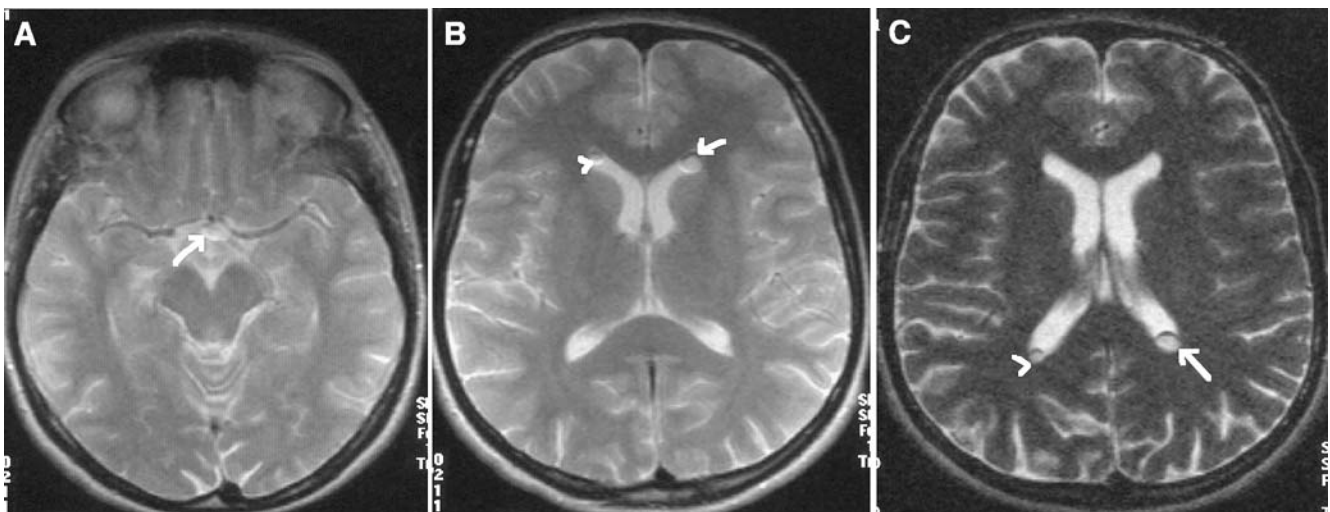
Intracranial silicone oil with the characteristic signal seen on Fig. 1. a Axial MRI image, T2 weighted. In the supine position, the optic chiasm and left optic tract (*arrow*) are surrounded by silicone oil droplets. b MRI image, T2 weighted. In the supine position, ovoid silicone oil droplets are visible in the horns of the lateral ventricles: a 47 mm droplet on the *right* (*arrowhead*) and an 8 mm
